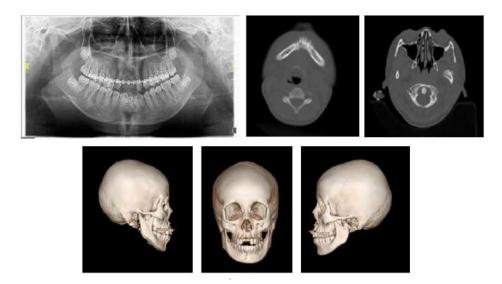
Panoramic X-ray and 3D CT scan of the head
